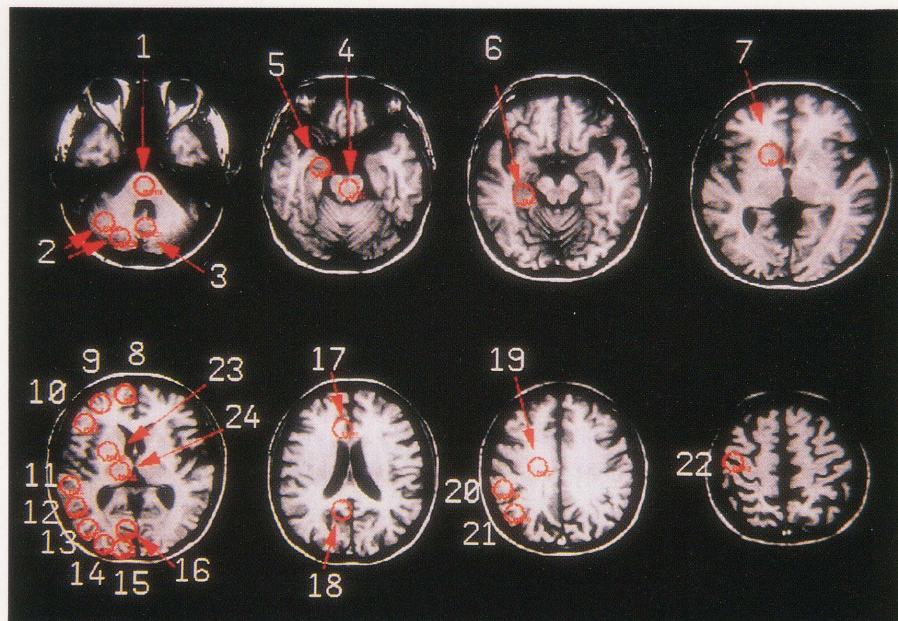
Reference MR images corresponding to the PET images and the location of regions of interest. Sixty images of MR T₁-weighted sequence were obtained in each subject with 2 mm axial spacing. The nearest MR images were chosen as an anatomical reference. According to the human brain atlas by Duvernoy,¹⁷ cortical gyri and deep brain structures were identified in the following regions; 1: pons, 2: cerebellar cortices (2 ROI), 3: cerebellar vermis, 4: midbrain, 5: entorhinal area of parahippocampal gyrus, 6: parahippocampal gyrus, 7: caudate nucleus, 8: superior frontal gyrus, 9: middle frontal gyrus, 10: inferior frontal gyrus (pars orbitalis), 11: superior temporal gyrus, 12: middle temporal gyrus, 13: middle occipital gyrus, 14: superior occipital gyrus, 15: occipital cuneus, 16: precuneus, 17 and 18: cingulate gyrus (anterior part and posterior part), and 19: semioval center, 20: supramarginal gyrus, 21: angular gyrus, 22: somato-sensory cortex, 23: lentiform nucleus, 24: thalamus. These ROIs were manually set on the CMRO₂ images by visual inspection.
